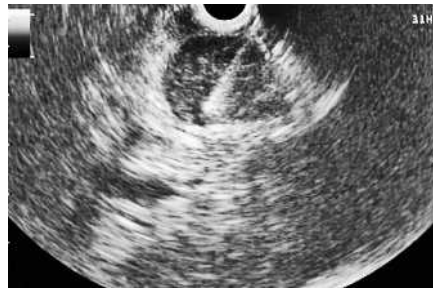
Endoscopic ultrasound image of the gastric stromal tumor, showing the Trucut needle after firing of the cutting sheath.
